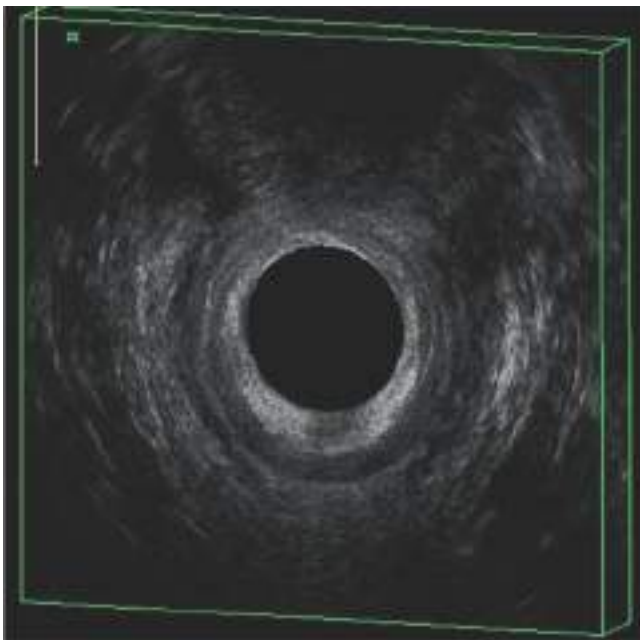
Three-dimensional ultrasound demonstrating the anterior sphincter defect. The internal sphincter appears hypoechoic (*dark*) and the external sphincter appears hyperechoic (*white*), with the incomplete ring anteriorly (*top*), indicating the sphincter defect.
